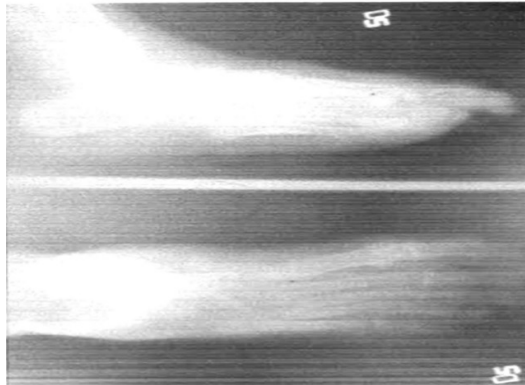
Radiograph showing thickening of the surrounding soft tissues with preserved interarticular space, suggestive of superinfected necrosis, without radiographically visible bone destruction.
